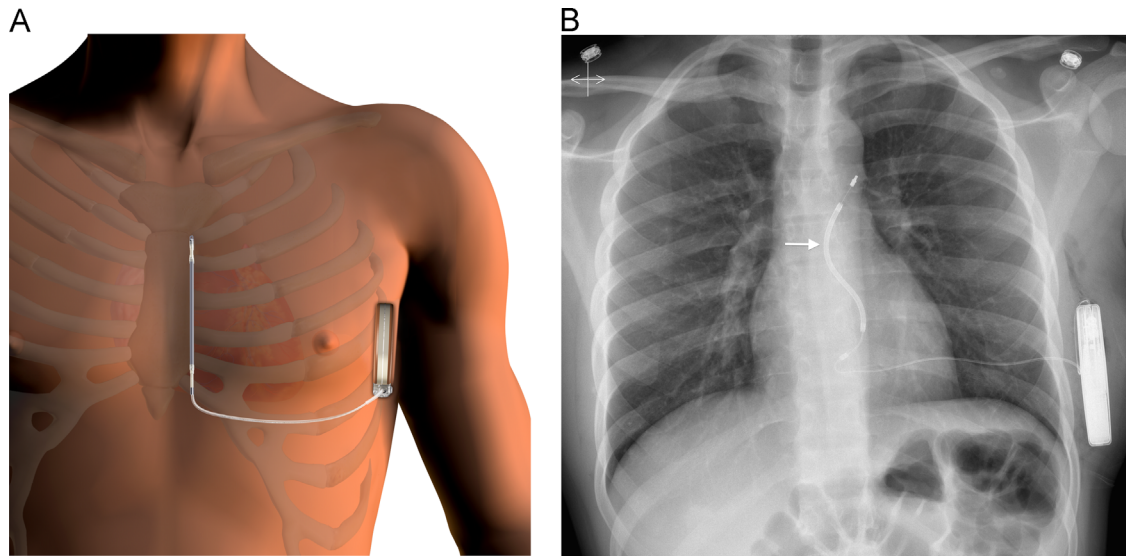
(A) Location of the pulse generator and the subcutaneous electrode after implantation of the subcutaneous implantable cardioverter defibrillator system. (B) Anteroposterior chest radiograph demonstrating a subcutaneous implantable cardioverter defibrillator system in situ with the single subcutaneous electrode delineated (arrow).
